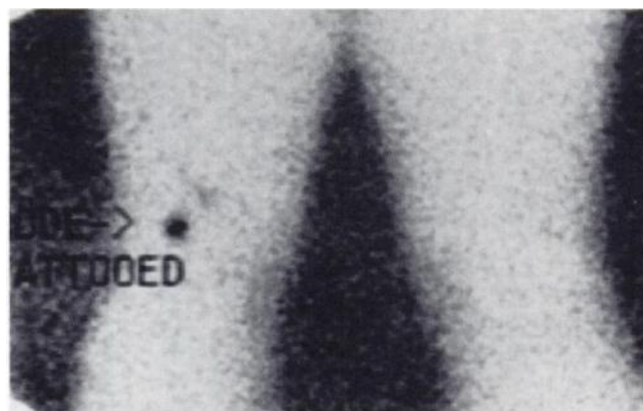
Pre-operative lymphoscintigraphy in a patient with a right foot melanoma. 450 μ Ci is injected into the dermis around the primary melanoma and scans of the patient 10 minutes after the injection of the radiocolloid show uptake in an in-transit SLN located in the right popliteal space. Since this is the first node in the chain from the primary site, by definition this is the SLN and needs to be harvested.
